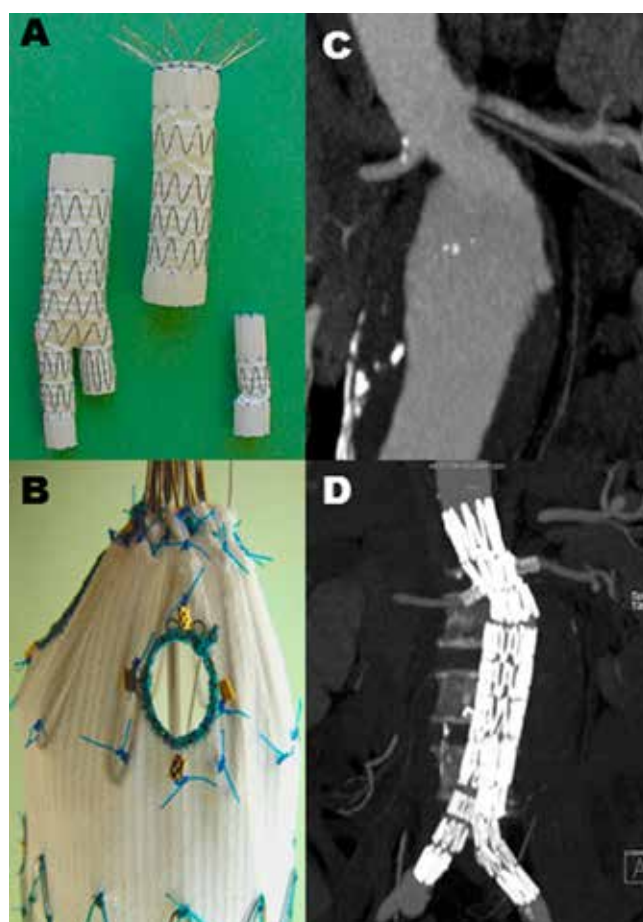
An *in vitro* deployed fenestrated stent-graft (Image A). Image B – a magnified view demonstrating a pre-planned fenestration within the proximal component. Image C – a preoperative CT scan of patient with a short and angulated aortic neck that is unsuitable for standard EVAR. Image D - post-operative CT scan (same patient as Image C) showing a deployed fenestrated stent-graft with exclusion of the AAA and patent visceral arteries.
